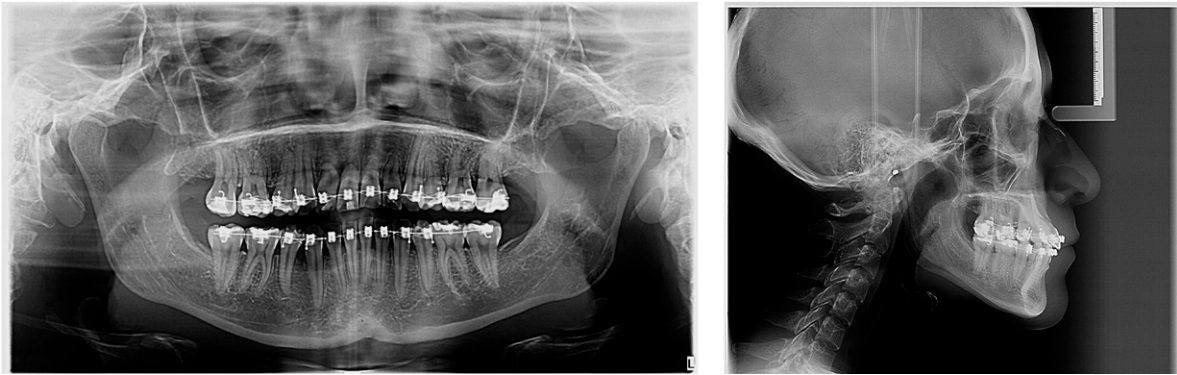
Final imaging studies, from left to right, orthopantomography, and lateral head film.
